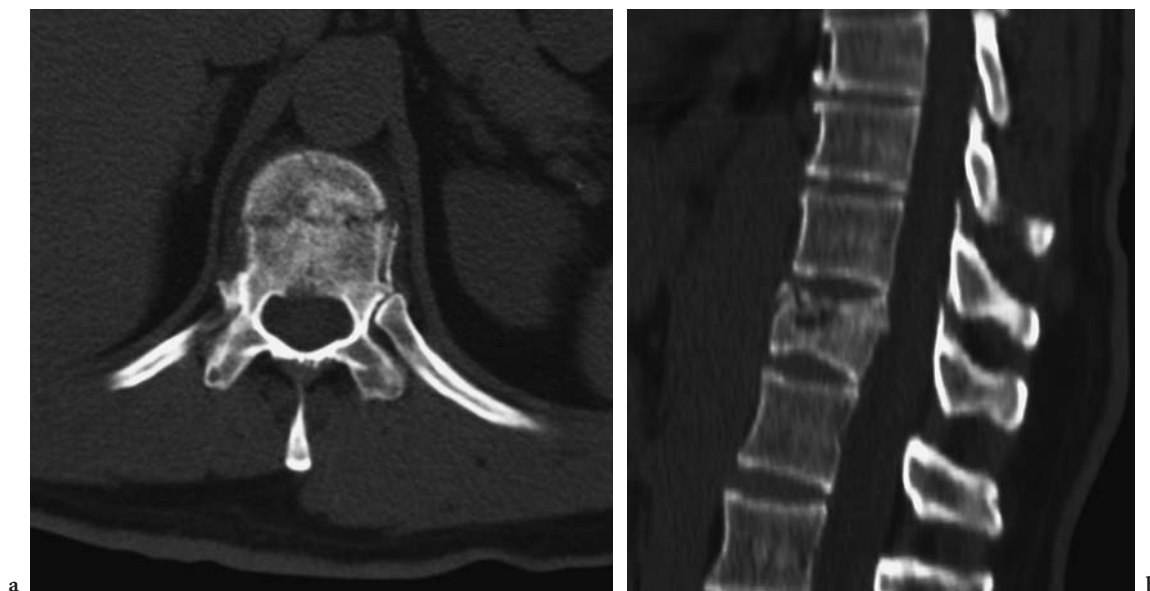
Stable burst fracture. a,b Axial CT and sagittal reconstructed image show that the fracture only involves the anterior half of the vertebral body and the posterior elements are spared. This indicates a stable burst fracture. This distinction may be difficult on plain radiographs
